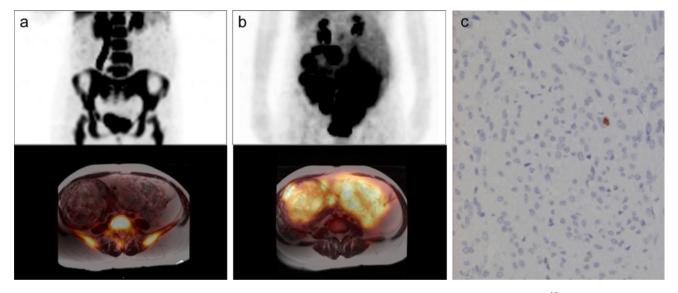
A representative case of leiomyoma. Maximum intensity projection PET images and transaxial PET images fused with MRI acquired with a¹⁸F-FLT and b¹⁸F-FDG PET, and c Ki-67
